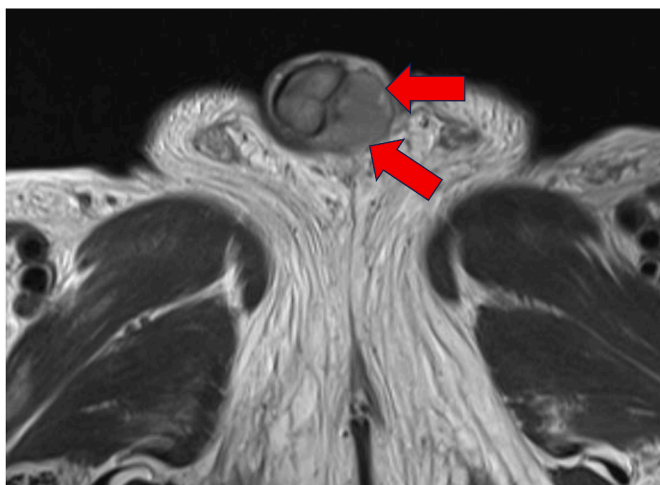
T2 sequence of MRI of the pelvis demonstrates a well-demarcated subcutaneous lesion on the ventral aspect of the penis (arrow).
